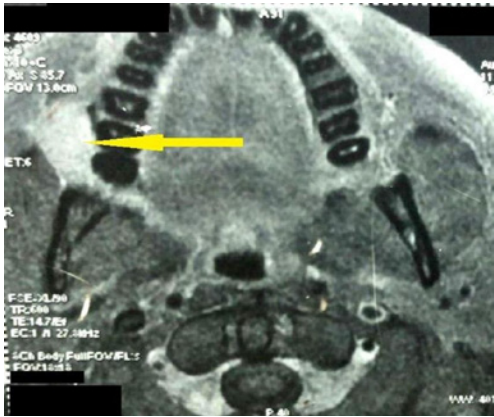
MRI face and neck (2013) showing a right buccal mucosa mass lesion with loss of interface with fat, alveolar margins and masseter (yellow pointer).
